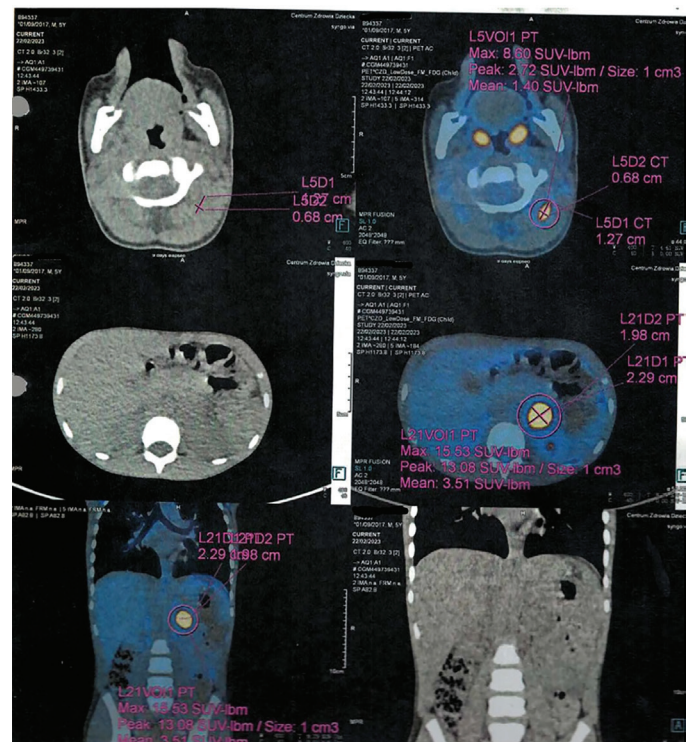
PET, Patient 5. A polycyclic lesion in the left adrenal gland with dimensions 22x20 mm with pathological accumulation of [18]-FDG (SUV_{max} FDG=13.4), above: the possibility of another lesion of dimensions 13x11 mm (SUV_{max} FDG=13.4)
